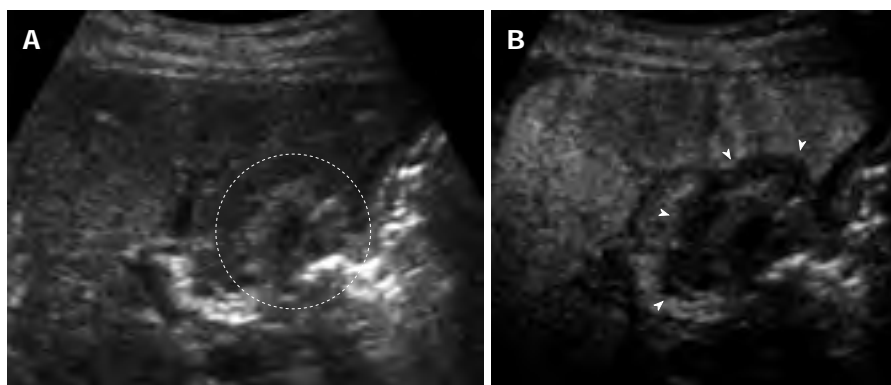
A 70-year-old man with 1.5 cm hepatocellular carcinoma after radiofrequency ablation. A: The ablated tumor is depicted as hyper echoic lesion (circle) on B-mode ultrasound (US). However, the boundary between ablated area and unablated liver tissue could not be identified clearly; B: Contrast-enhanced US using Sonazoid shows the defect (arrows) in the Kupffer phase. The ablation margin is shown as low echoic zone surrounding the ablated tumor.
